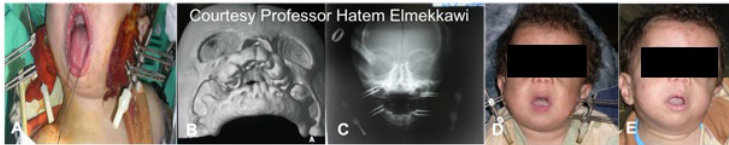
Pierre Robin Sequence. A. Bilateral extra-oral mandibular devices in place. B. 3D image showing mandibular retrognathia. C. PA radiograph showing the gap and the devices in place. D. Distraction devices in place after a period of distraction. E. Post-operative picture.
